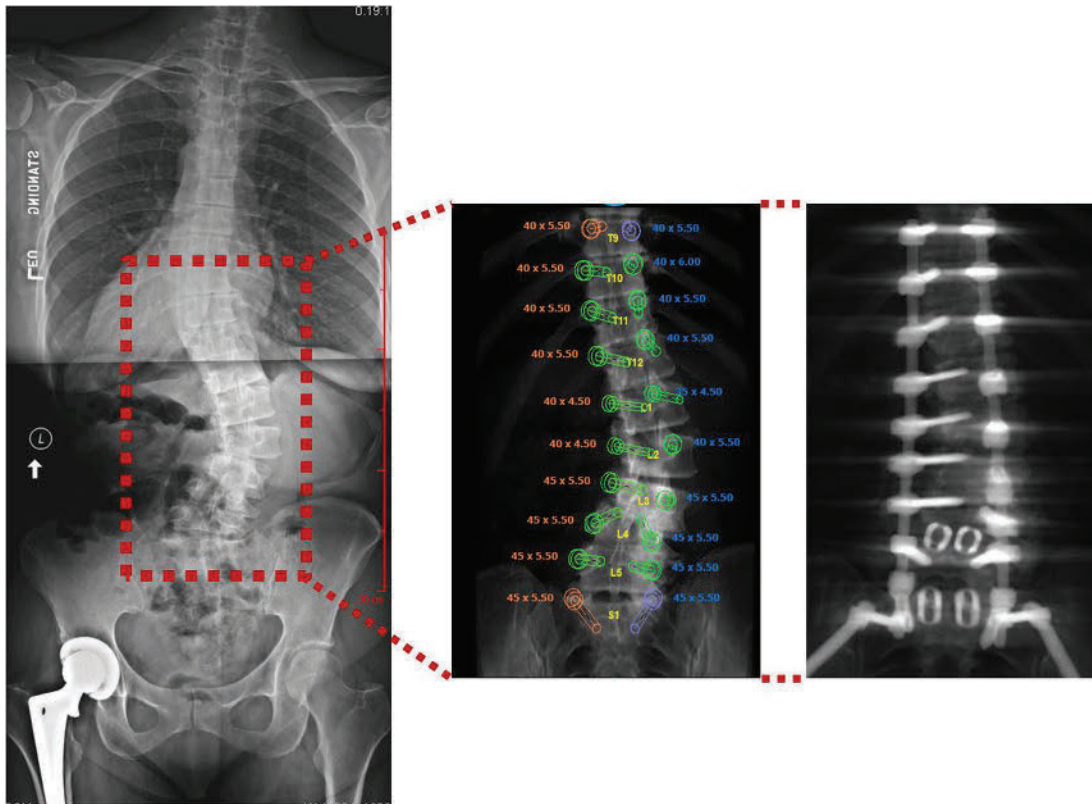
The x-ray on the left shows a patient with thoracolumbar scoliosis. The middle image demonstrates the pre-operative blueprint showing the location where screws will be placed during scoliosis correction surgery. The x-ray on the right shows the final location of the implants after surgical correction.
